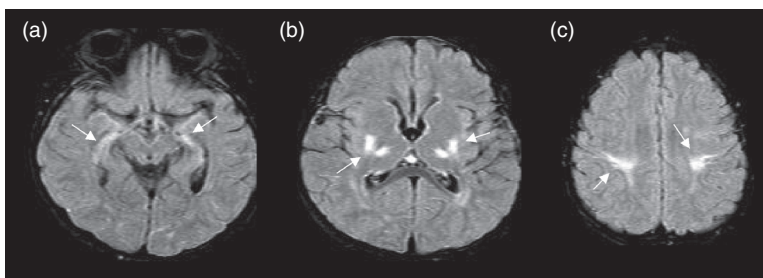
Profound HIE: chronic phase with (a–c) bilateral hippocampal, putaminal, thalamic, and paracentral high intensities (arrows) on axial FLAIR MRI.
